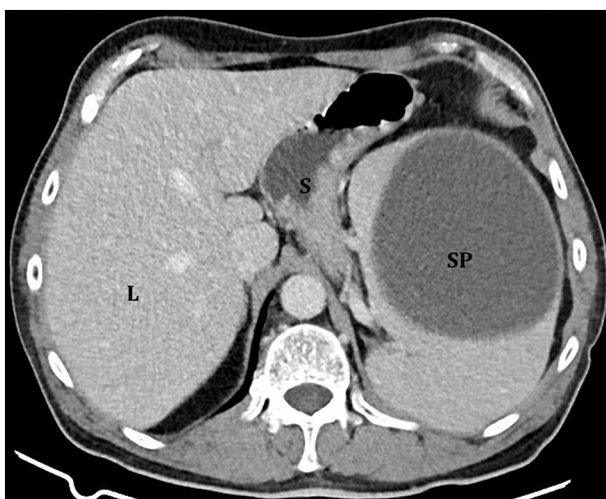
CT scan of the abdomen show compression of the stomach (S) by a low density, a non-enhancing cystic mass of the spleen (SP).
